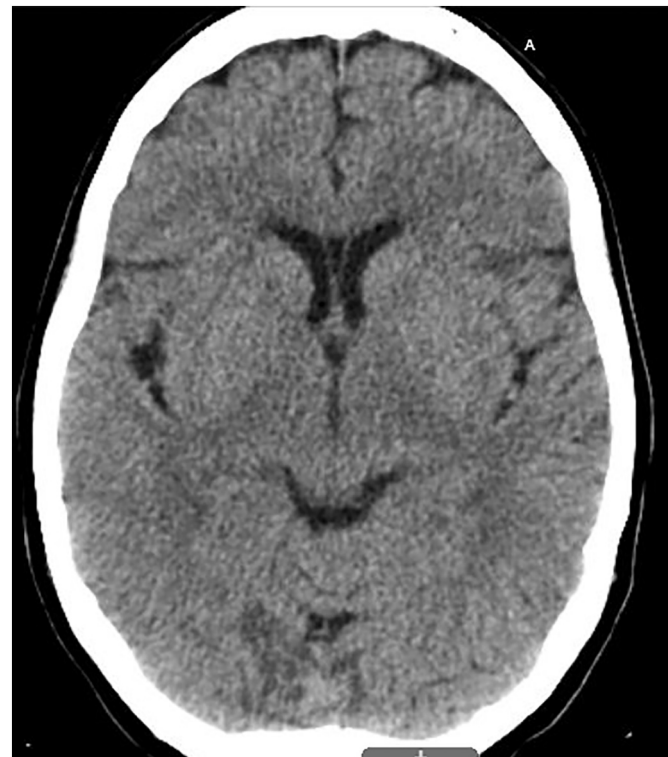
Non-contrast head CT demonstrating nonspecific heterogeneous low-attenuation lesion within the medial right occipital lobe.
